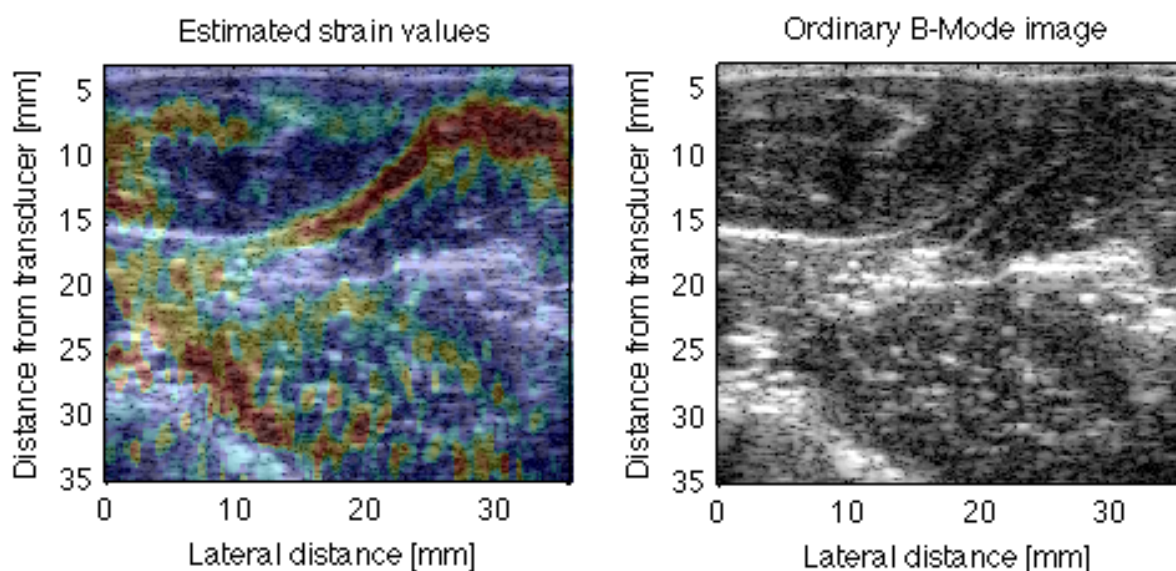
Transversal recording on the lower arm with estimated strain values on the left hand side, and the ordinary B-mode image on the right hand side. Recording made with a 7.5 MHz Ultrasonix transducer, and filtered by a FIR bandpass filter with cut off frequencies of 3 MHz and 9 MHz. Data demodulated with a demodulation frequency  $f_d = 6$  MHz. Time delay values were estimated by a linear model of  $\hat{\tau}$  within a window size of 3.4 mm
